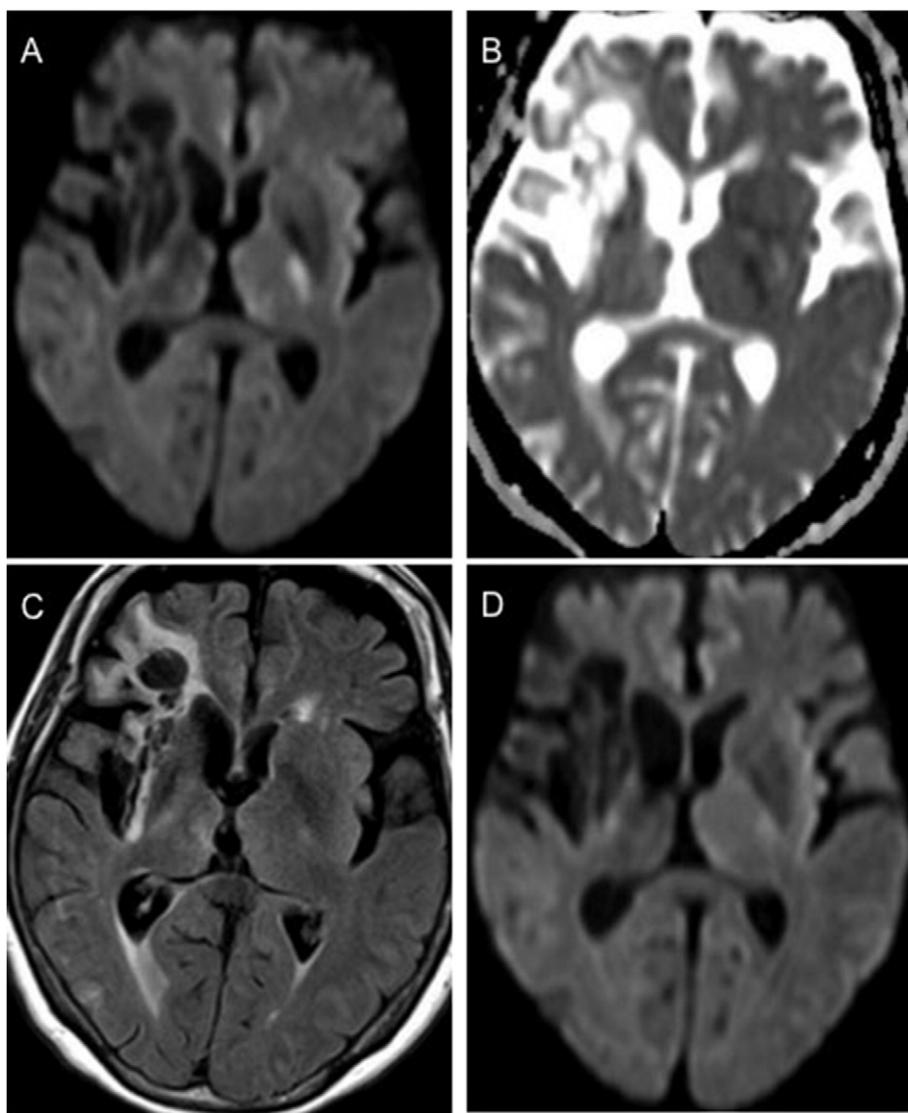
Example of a hypoglycemic patient on MRI (case 6). DWI on admission shows a hyperintense lesion in the left internal capsule (A) with decreased ADC (B). This lesion appears normal on FLAIR (C). The DWI performed one day later shows only faint lesion (D).
